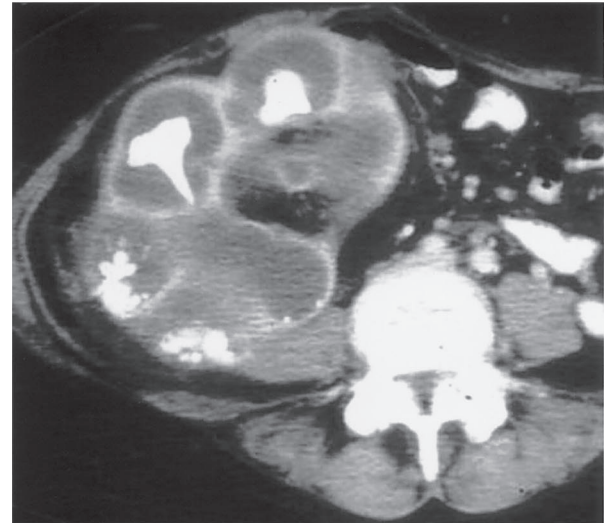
(a) A bear's paws. (Photograph entitled "Bad Boys of the Arctic" reprinted with permission from Thomas D. Mangelsen, Inc.) (b) Contrast material-enhanced CT scan (same patient as in Fig 2) demonstrates a centrally obstructing stone with replacement of the renal parenchyma by low-attenuation collections in a "hydronephrotic" pattern. Note the lack of dilatation of the renal pelvis and infundibula. (c) CT scan obtained at a slightly lower level shows the fragments of a staghorn calculus within the parenchymal collections, which exhibit marginal enhancement. The pattern seen at CT resembles a bear's paw.
